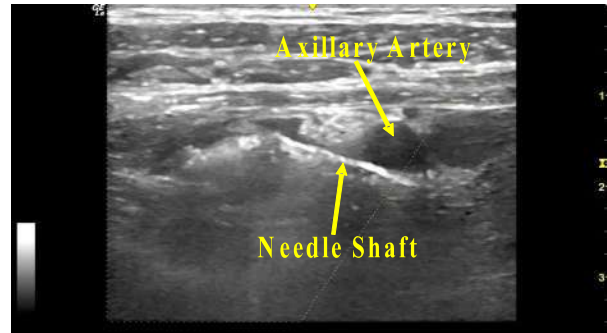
A transverse sonogram showing the axillary artery and needle shaft in CIB and angle of needle shaft is noted to be at 45 to 60 degree
